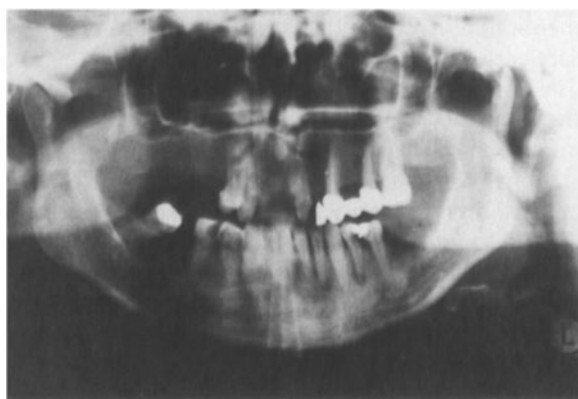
X-ray of the same tumor as in Figs. 22.1 and 22.3
